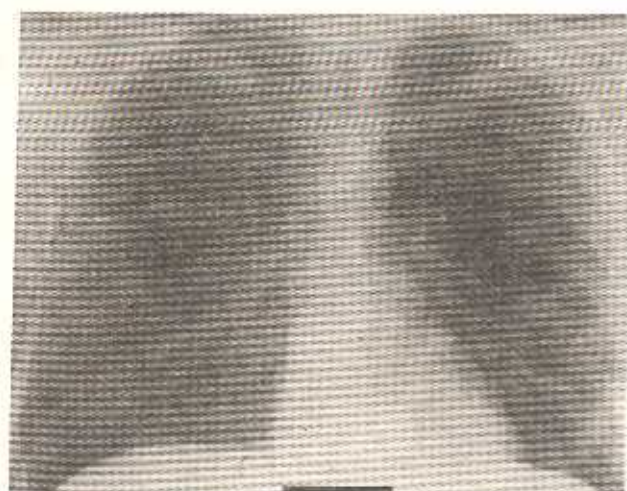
X-Ray Chest (PA View) of IS at Arctic
